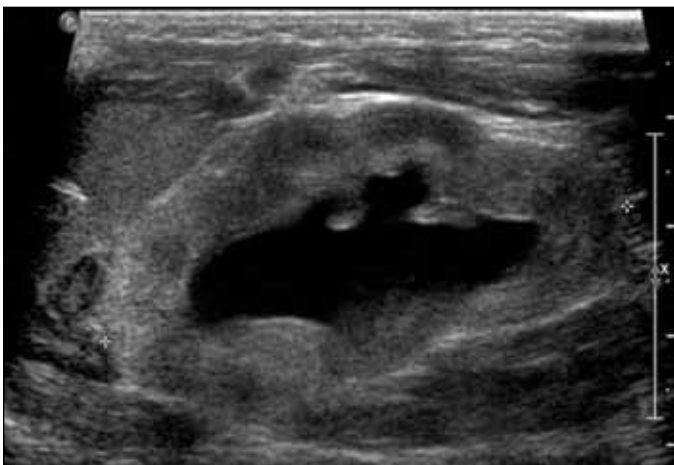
Renal and bladder ultrasound on Day 1 of life with bilateral echogenic kidneys and Grade 3 hydronephrosis.
